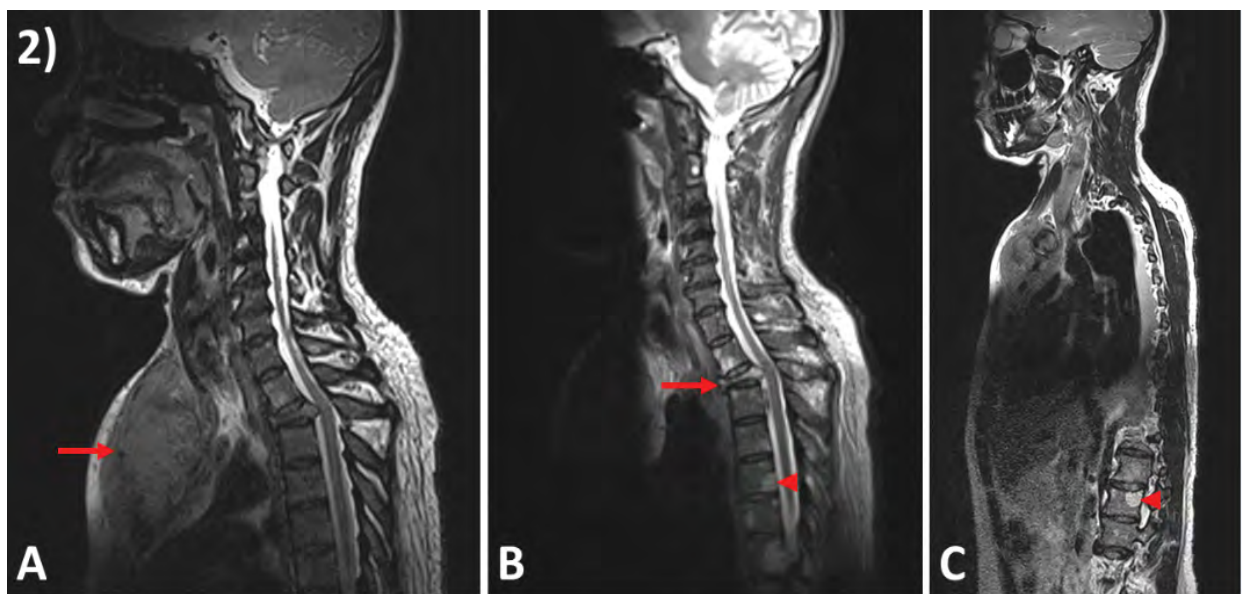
Magnetic resonance imaging (MRI) of the spinal cord. (A) Soft tissue mass in sternum with extension into manubrium (arrow); (B) Pathobiological fracture involving the 4th thoracic vertebra (T4; arrow) with associated focal spinal stenosis; (B, C) Diffuse marrow infiltration of thoracic and lumbar vertebrae (arrowheads).
